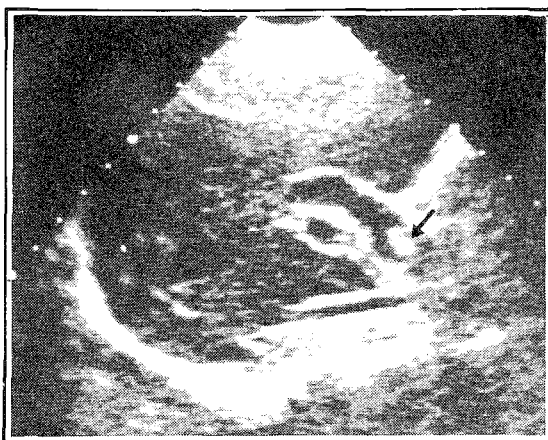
a) Oblique ultrasound section showing an echogenic focus casting acoustic shadow within a dilated common duct (arrow) consistent with a calculus.
